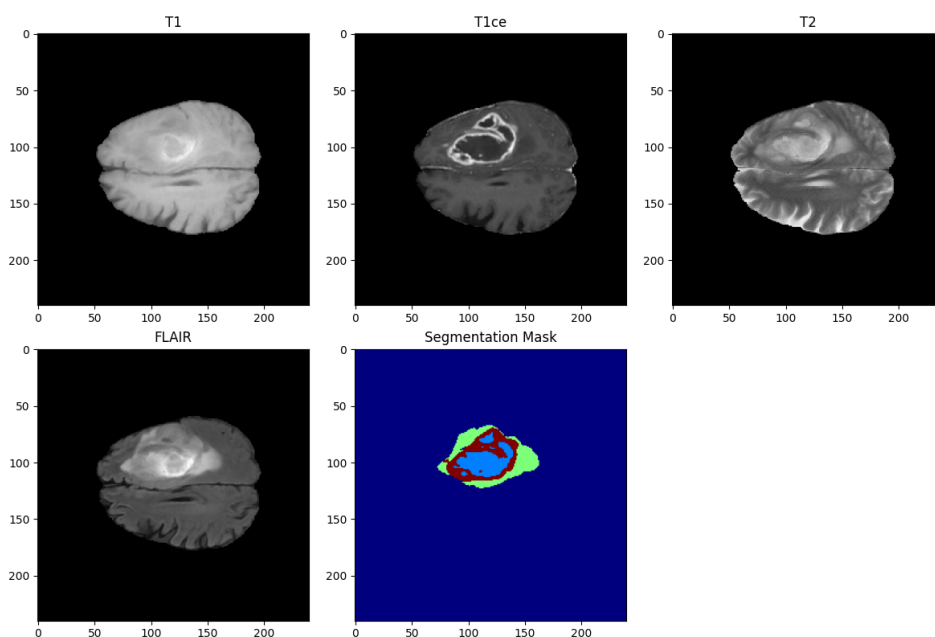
Brats modalities: T1, T1ce, T2, and T2-FLAIR.
